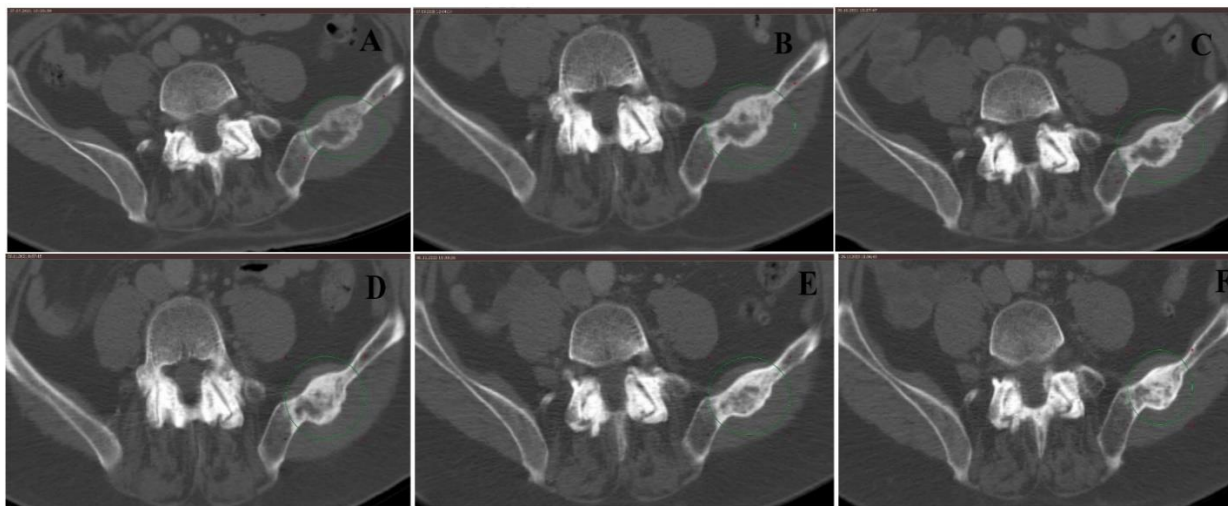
Images of the ilium metastasis according to the CT. A – before targeted therapy, B - after 1,5 months, C – after 3 months, D – after 4,5 months, E – after 15,5 months, F - after 30 months
